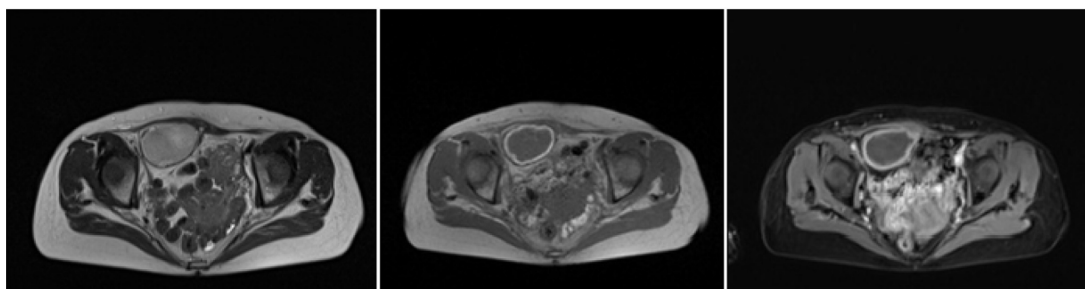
Abdominal MRI with contrast at diagnosis of RSH.
